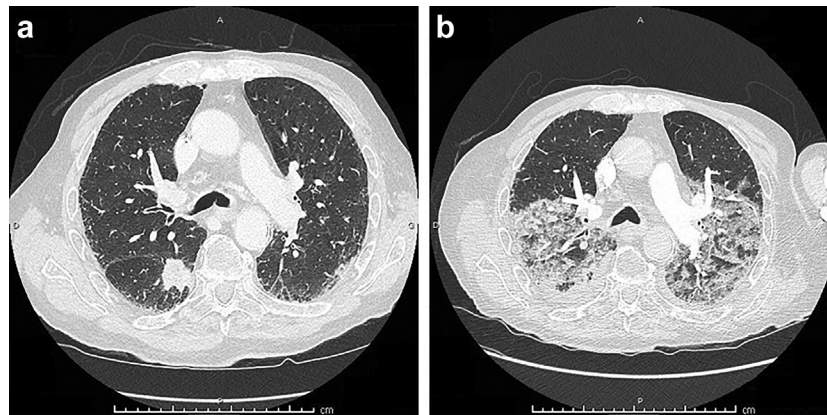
Chest computed tomography scan. (a) November 26, 2020; (b) December 3, 2020.
